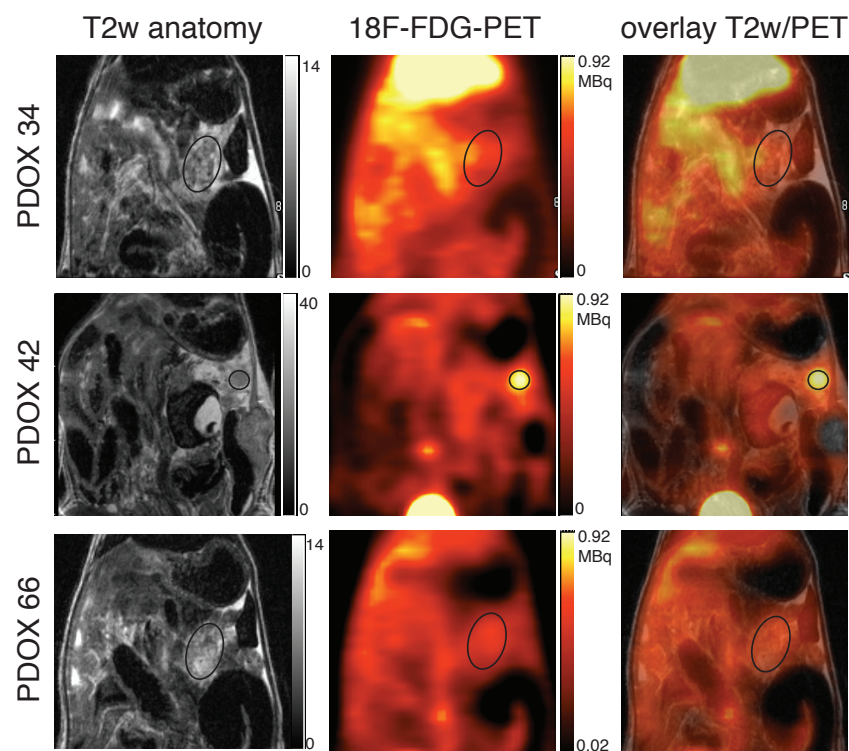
MRI/PET images of PDOXs. The left panel shows the MRI images, the middle panel displays PET images and the right panel indicates an overly of MRI and PET.
